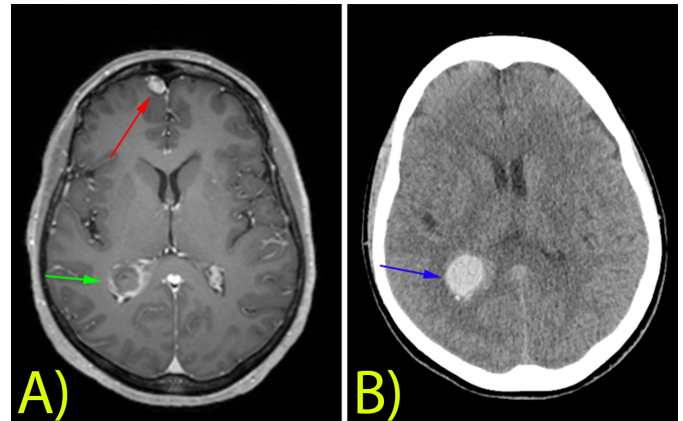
T1 Contrast enhancing sequence(A), right atrial peripherally contrast-enhancing lesion is shown with the green arrow, while right frontal metastasis is shown with red arrow. On CT imaging (B), note the hemorrhagic lesion in the right ventricle, shown with a blue arrow
